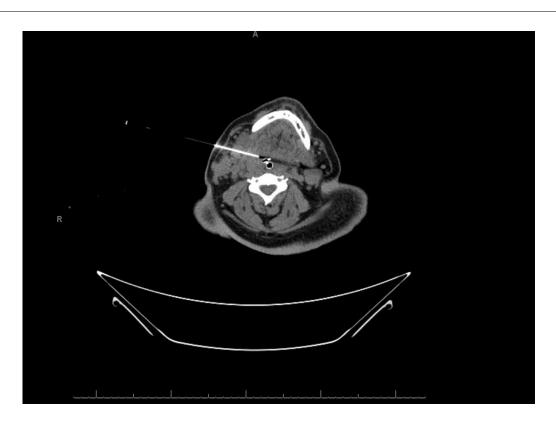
Axial CT of head and neck with contrast, hospital day 3 (June 2, 2023), intraprocedural image showing the needle in target collection.
